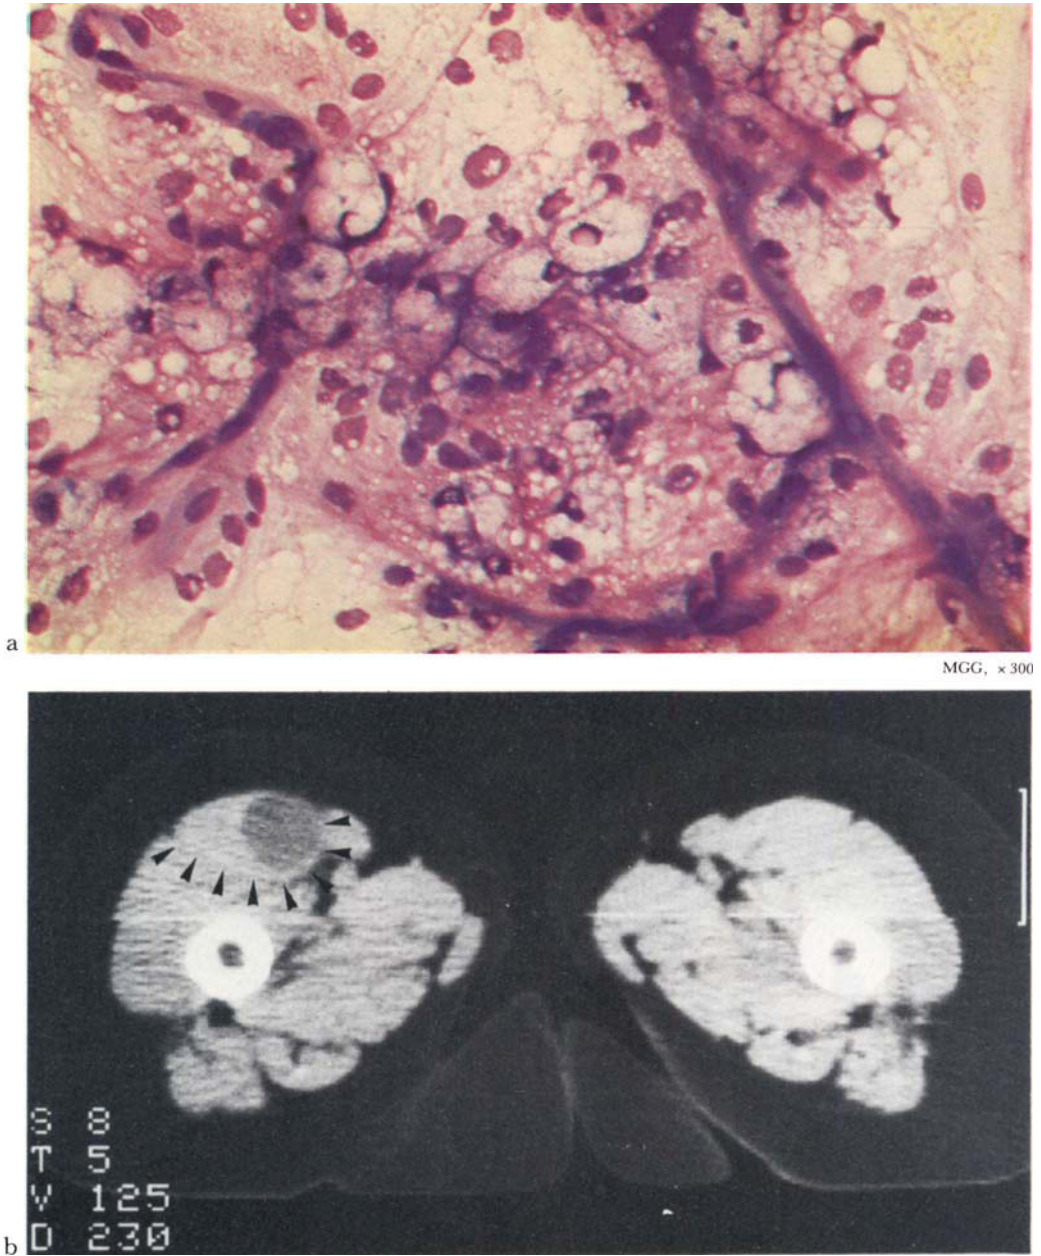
Aspiration cytology, computed tomography and primary myectomy.
